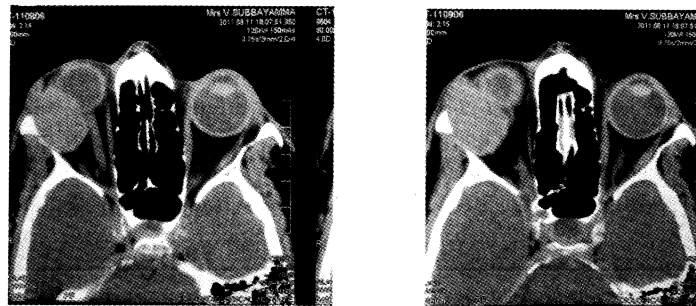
Axial view of CT scan of orbit
